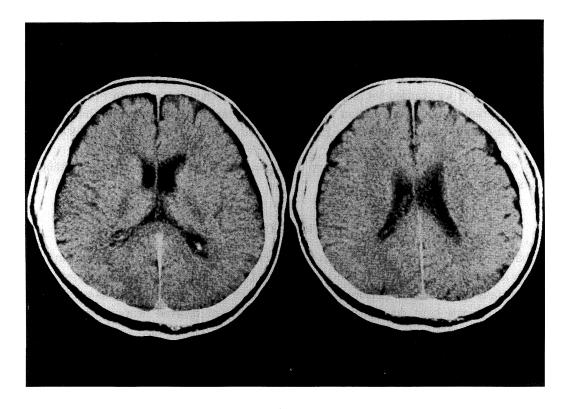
Brain CT was carried out immediately after restoration of the patient's spontaneous circulation. The basal ganglia and the thalamus and corticomedullary junction of the cerebrum are indistinct areas, These findings indicate the presence of cytotoxic edema. No other abnormal findings were detected, including hemorrhage and infarction.
